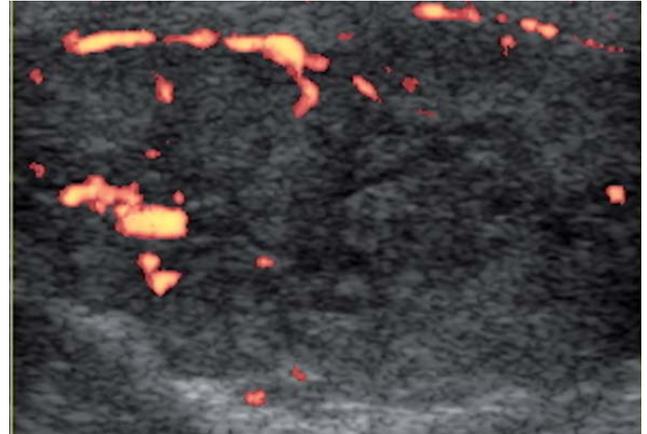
Longitudinal ultrasound image of a canine thyroid carcinoma (with Power Doppler). Note the heterogeneity, increased size and rounding of the lobe. The vascularization of the lobe is increased.
